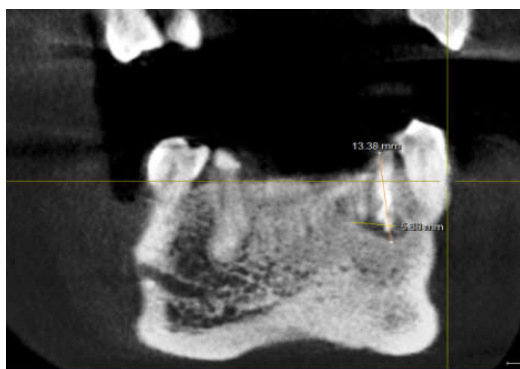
Preoperative cone beam computed tomography showing 3.28 mm size of the lesion horizontally
